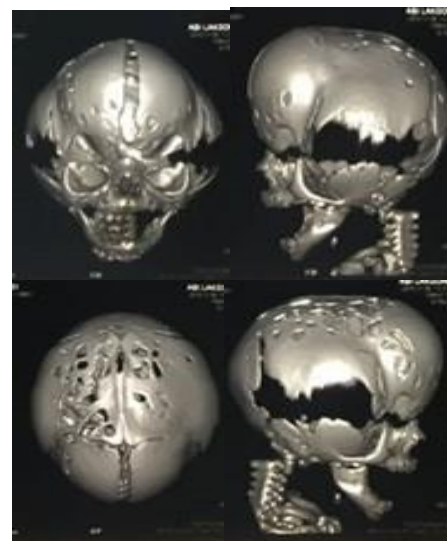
Cranium CT performed; 9
